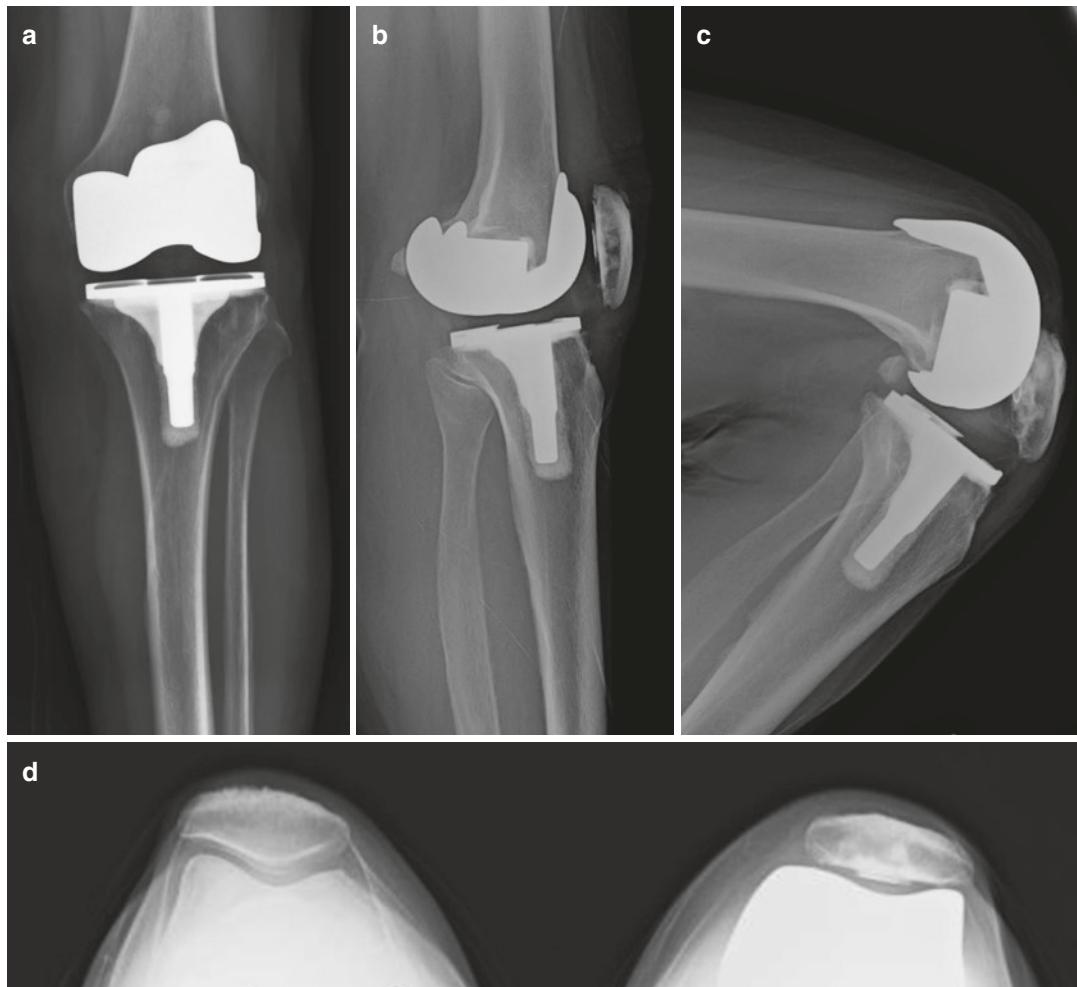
(a–d) Preoperative anteroposterior, lateral flexion and extension, and sunrise view radiographs of a well-aligned, well-fixed left total knee arthroplasty
